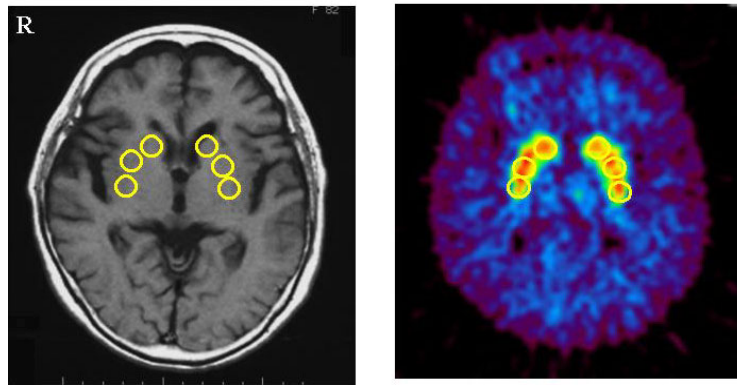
ROI-figure and application for case 11. Left = MRI image of case 11. Right = PET image of case 11. OM = orbito-meatal line, Yellow circles = ROI applied for striatal part.
